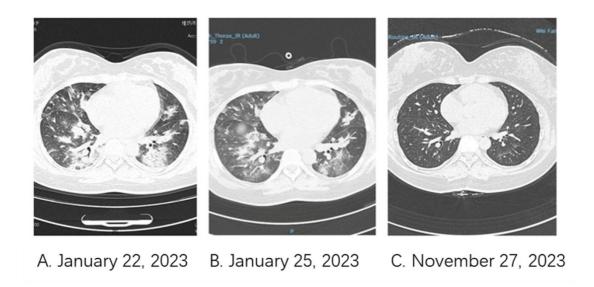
Chest CT of patient on different dates
